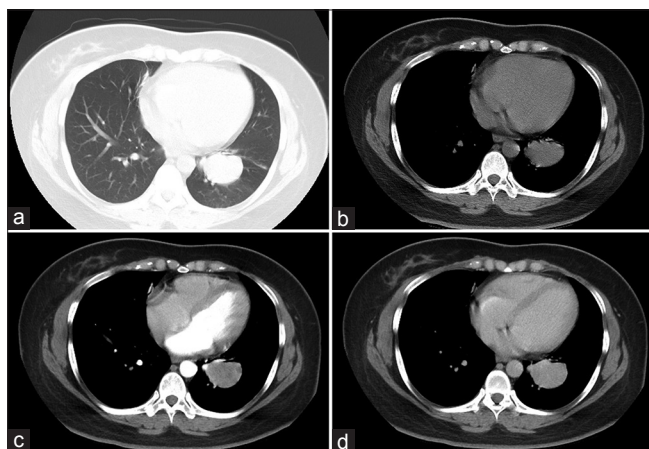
Computed tomography findings. (a) A mass was observed in the anterior basal segment in the left lower pulmonary field, with a clear boundary and irregular margins. (b) No swelling of mediastinal or hilar lymph nodes and no bilateral pulmonary effusion were observed. (c, d) Enhanced CT showed uniform enhancement in the venous phase and arterial phase
